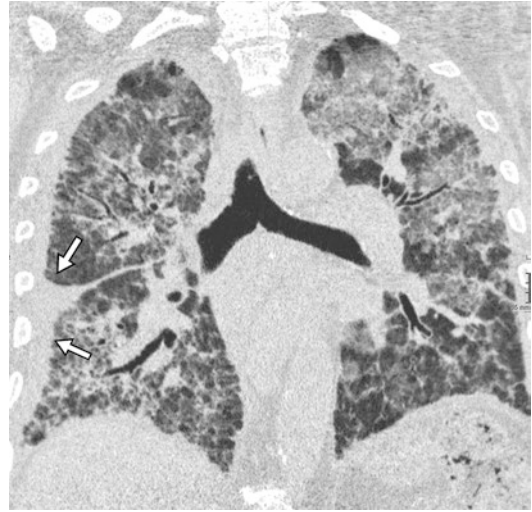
Acute fibrinous and organizing pneumonia (AFOP) in a 62-year-old man. Coronal CT shows diffuse bilateral ground-glass opacities and peribronchovascular consolidations. Note an associated right pleural effusion (arrows)
